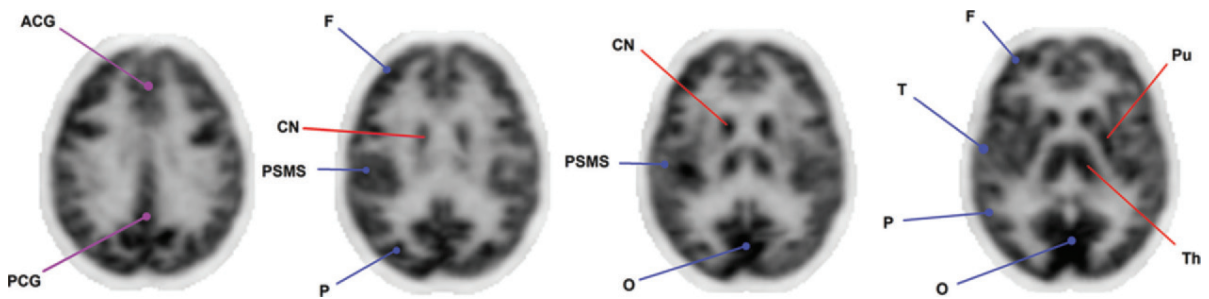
Sequential axial brain FDG PET images (transformed to a standardized, stereotaxic anatomic orientation [Talairach brain atlas space]) obtained in a normoglycemic patient starting approximately 30 minutes after injection show a stable pattern of cerebral uptake. The spatial resolution of PET allows identification of the cortical gray matter structures, white matter tracts, subcortical structures, and cerebellum. *ACG* = anterior cingulate gyrus, *CN* = caudate nucleus, *F* = frontal lobe, *O* = occipital lobe, *P* = parietal lobe, *PCG* = posterior cingulate gyrus, *PSMS* = primary sensorimotor strip, *Pu* = putamen, *T* = temporal lobe, *Th* = thalamus.
